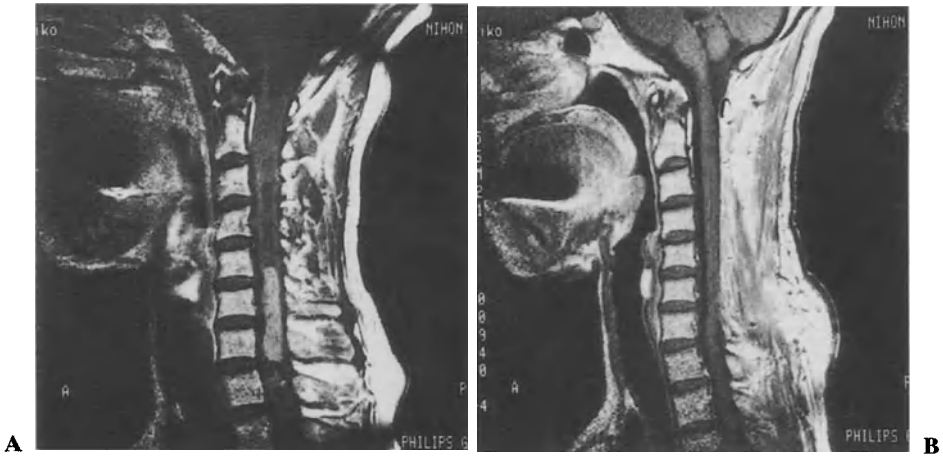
Magnetic resonance imaging scans showing location of intramedullary spinal cord tumor (case 5) before (A) and after (B) surgery
